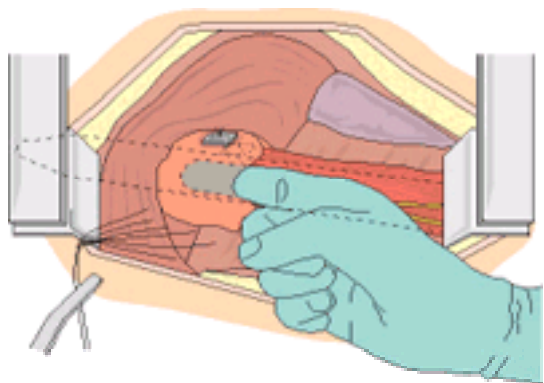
Transthoracic Nissen fundoplication. (5) The tip of the surgeon's finger should be able to be inserted between the fundoplication and the esophagus containing the 60-Fr bougie. The U-stitch is located on the right anterolateral wall of the esophagus.
